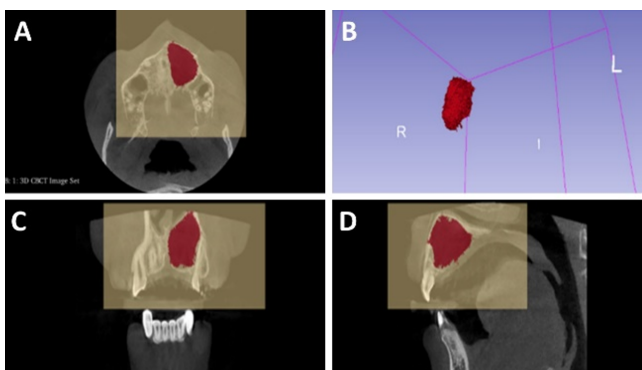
Cyst segmentation before marsupialization in an 18-year-old male patient. A: Axial cone beam computed tomography image showing the segmented cyst (red area). B: 3D reconstruction of the cyst. C: Coronal view of the lesion. D: Sagittal view demonstrating cyst extension.
